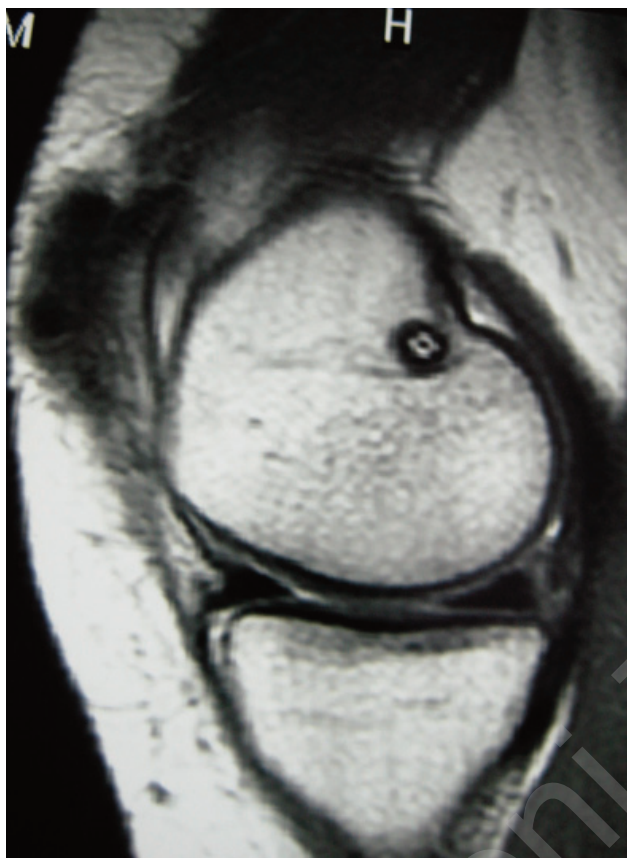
Magnetic resonance image showing the femoral tunnel after reconstruction of the MPFL. It is crucial to position the tunnel correctly, in such a way as to reproduce the biomechanical behavior of the original ligament.
